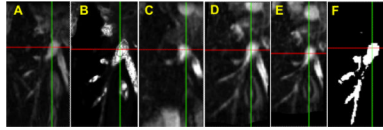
Registration result for pulmonary artery (PA) in MRI image of lamb. A Reference blood vessel, B Vesselness image, C Result of non-weighted registration, D Result of single-weighted registration, E Result of dual-weighted registration, F Manually segmented region from A.
